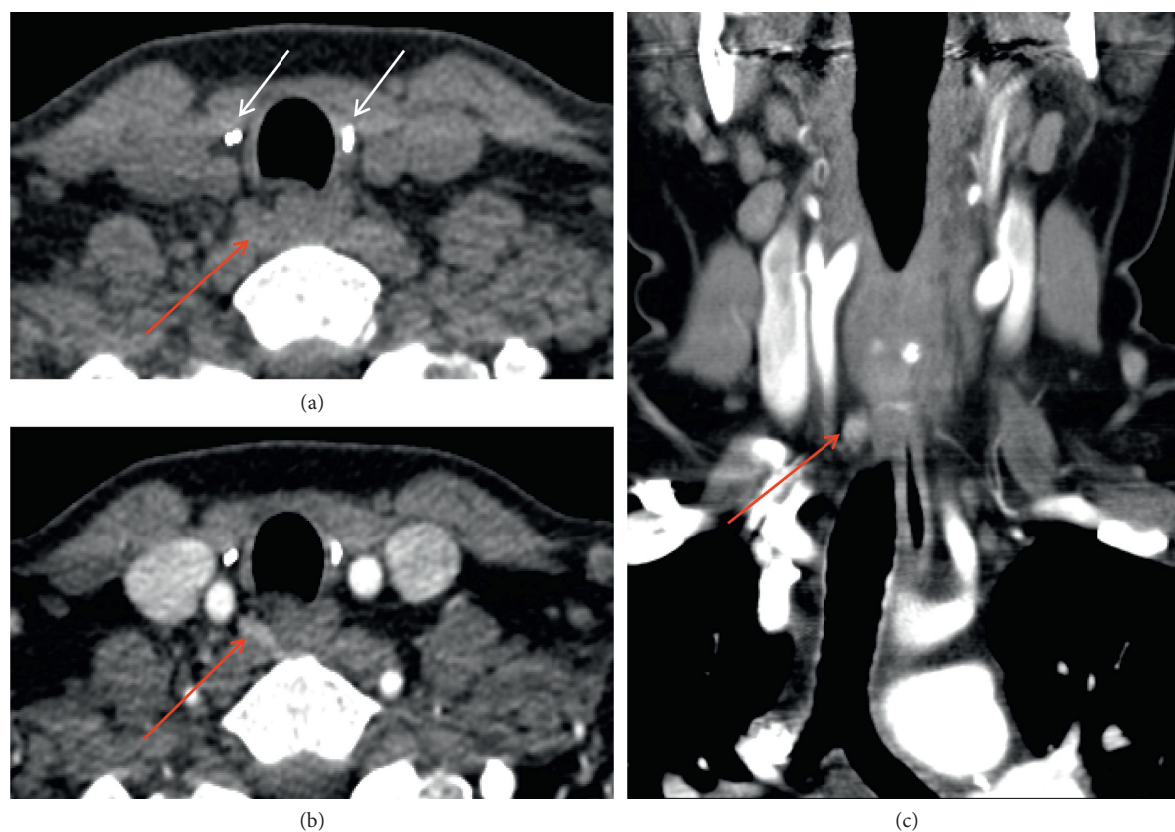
Ectopic parathyroid adenoma on four-dimensional computed tomography (4DCT). A patient presents with recurrent hyperparathyroidism after prior total thyroidectomy with benign pathology and prior bilateral inferior parathyroidectomy. Axial precontrast 4DCT (a) shows ectopic adenoma (red arrow) in the right para-retroesophageal region almost at the prevertebral fascia, deep to right surgical clips (white arrows). The ectopic adenoma is hyperenhancing on axial postcontrast (b) and coronal (c) early arterial phases (red arrows).
